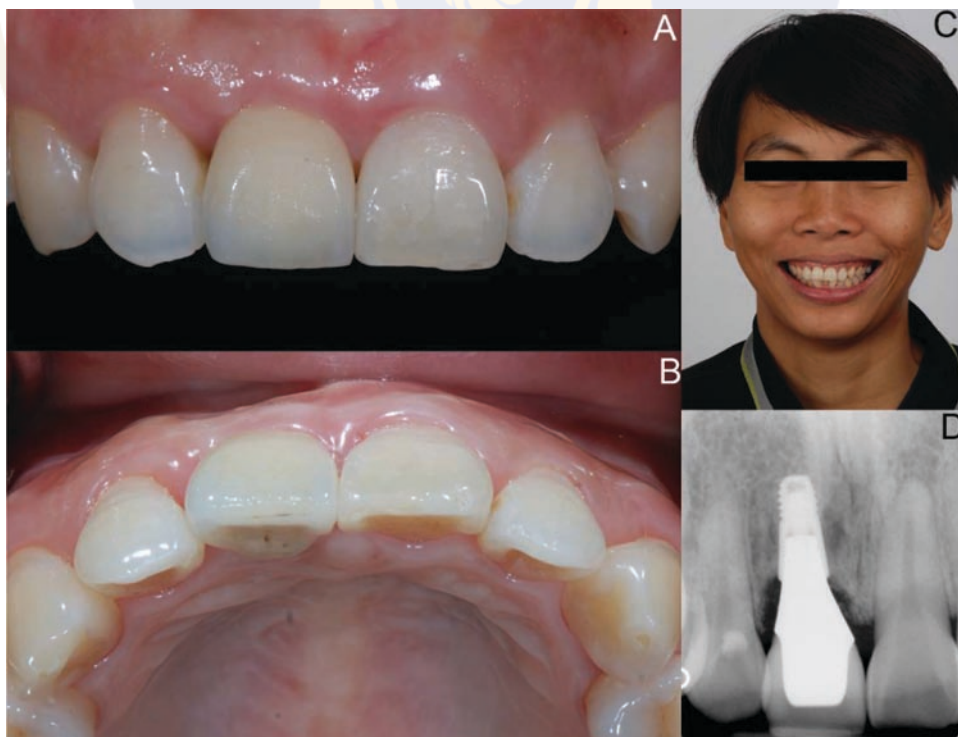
4-month recall, the patient reported satisfaction with both function and esthetics (A, B), the frontal views of patient (C) and the peri-apical radiograph showed no marginal bone loss (D).
